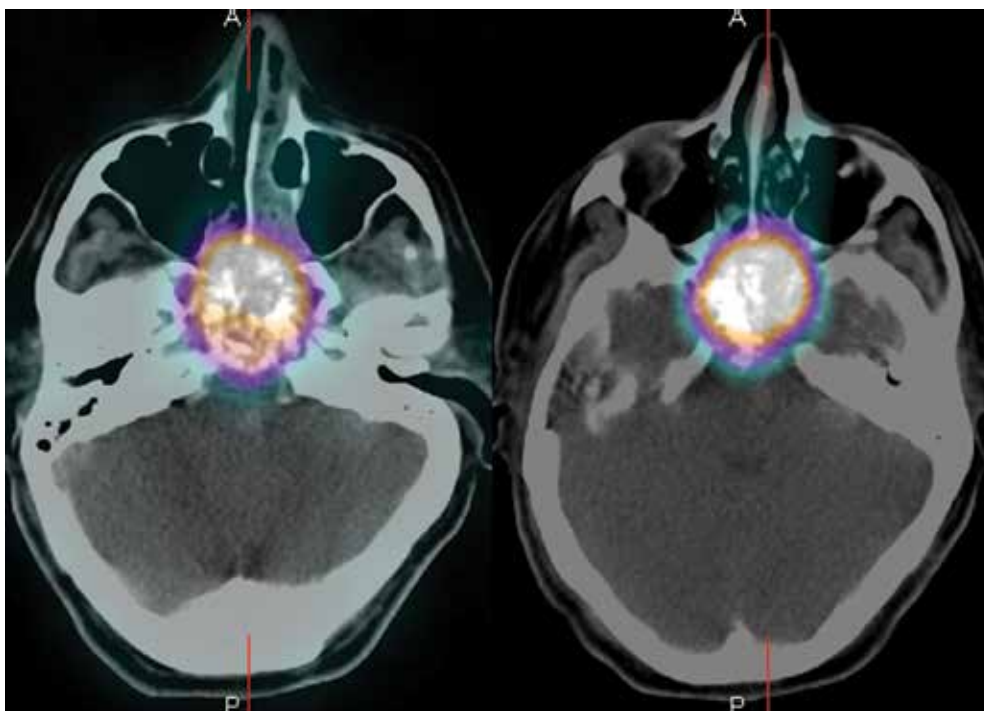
A 52-year-old male with neuroendocrine carcinoma of nasopharynx (case number 1). ^{99m}Tc -EDDA/HYNIC-TOC SPECT/CT was done as preoperative staging. On SPECT/CT images (axial view) is shown increased radiopharmaceutical uptake in the primary tumor with intensive bone destruction at the base of skull. SPECT/CT, single photon emission computed tomography/computed tomography
